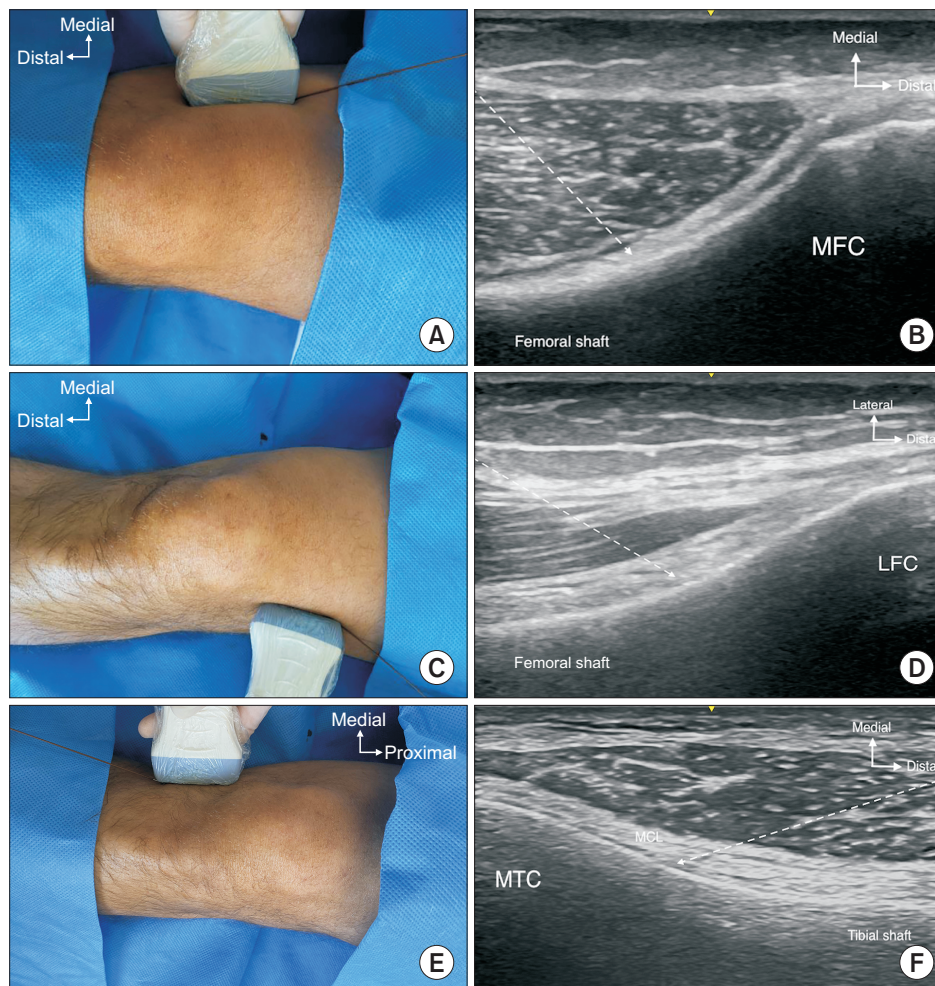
Transducer placement and ultrasound images with radiofrequency cannula for SMGN (A, B), SLGN (C, D), and IMGN (E, F). White dashed arrows indicate the needle trajectory. SMGN: superior medial genicular nerve, SLGN: superior lateral genicular nerve, IMGN: inferior medial genicular nerve, MFC: medial femoral condyle, LFC: lateral femoral condyle, MTC: medial tibial condyle, MCL: medial collateral ligament.
